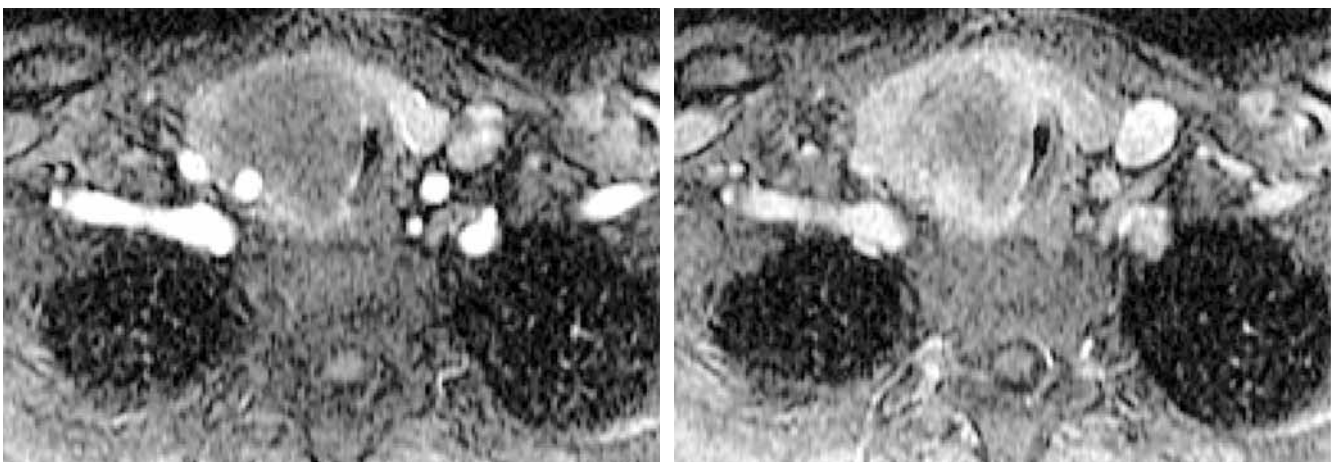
On dynamic MRI with fat suppression, the mass shows mild contrast enhancement from the periphery with time.
